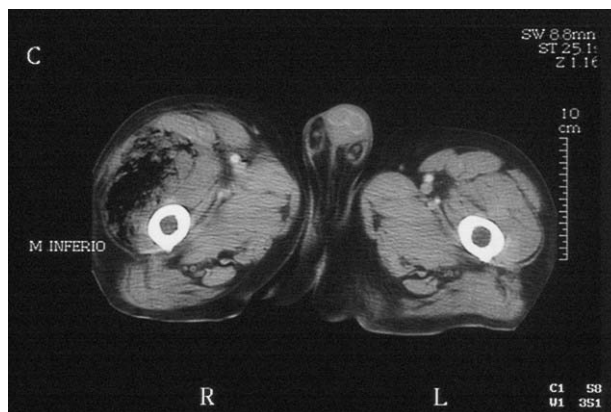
CT scan of lower limbs at groin level. Gas bubbles are observed dissecting the vastus lateralis muscle and producing a proximal curving of the fascia lata.
